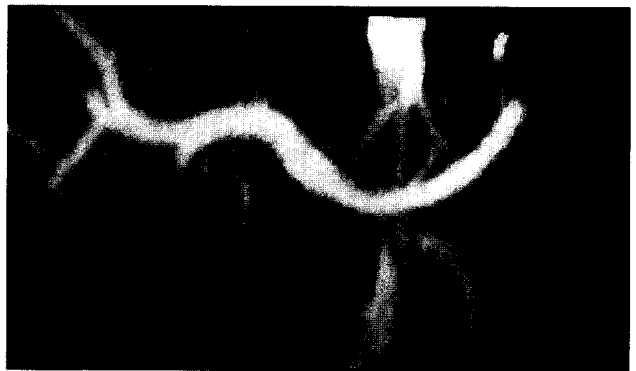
Three-dimensional reconstruction of a CT angiogram showing a grade 3 lesion with narrowing of the vessel by the tumor of greater than 50% of the circumference (*arrow*).
